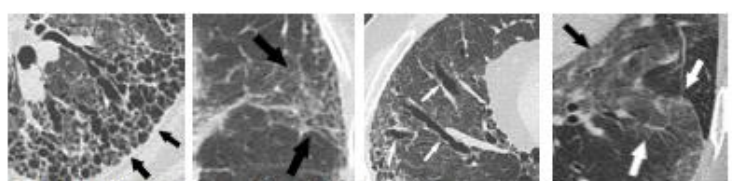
Different CT patterns of interstitial pneumonias
